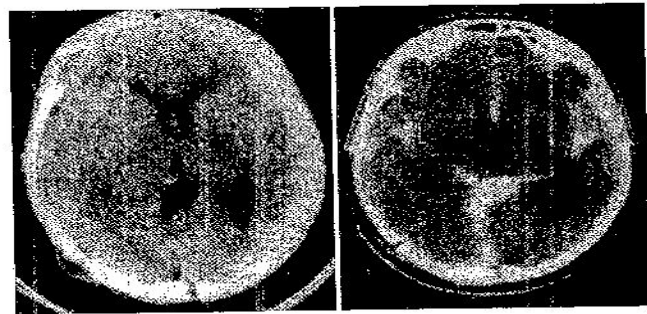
Case 2. *Left:* Postoperative CT scan obtained at the level of the quadrigeminal plate revealing an eccentric calcification located at the periphery of a round cavity. It is unclear whether this represents a tumor remnant. *Right:* Computerized tomography cisternography demonstrating filling of the cavity by free-flowing CSF.
